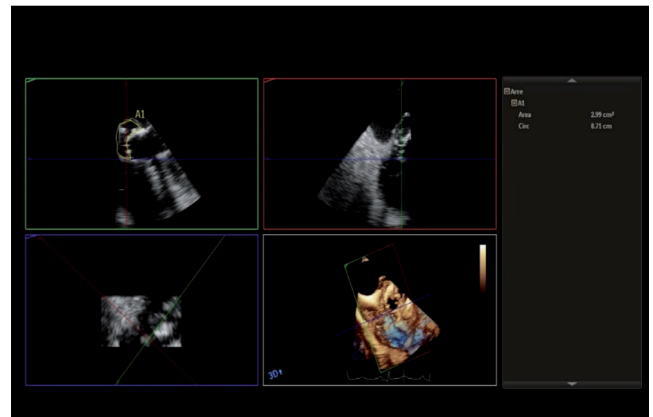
3D transesophageal echocardiography. Multiplane reconstruction for evaluation of pseudoaneurysm area and circumference.
